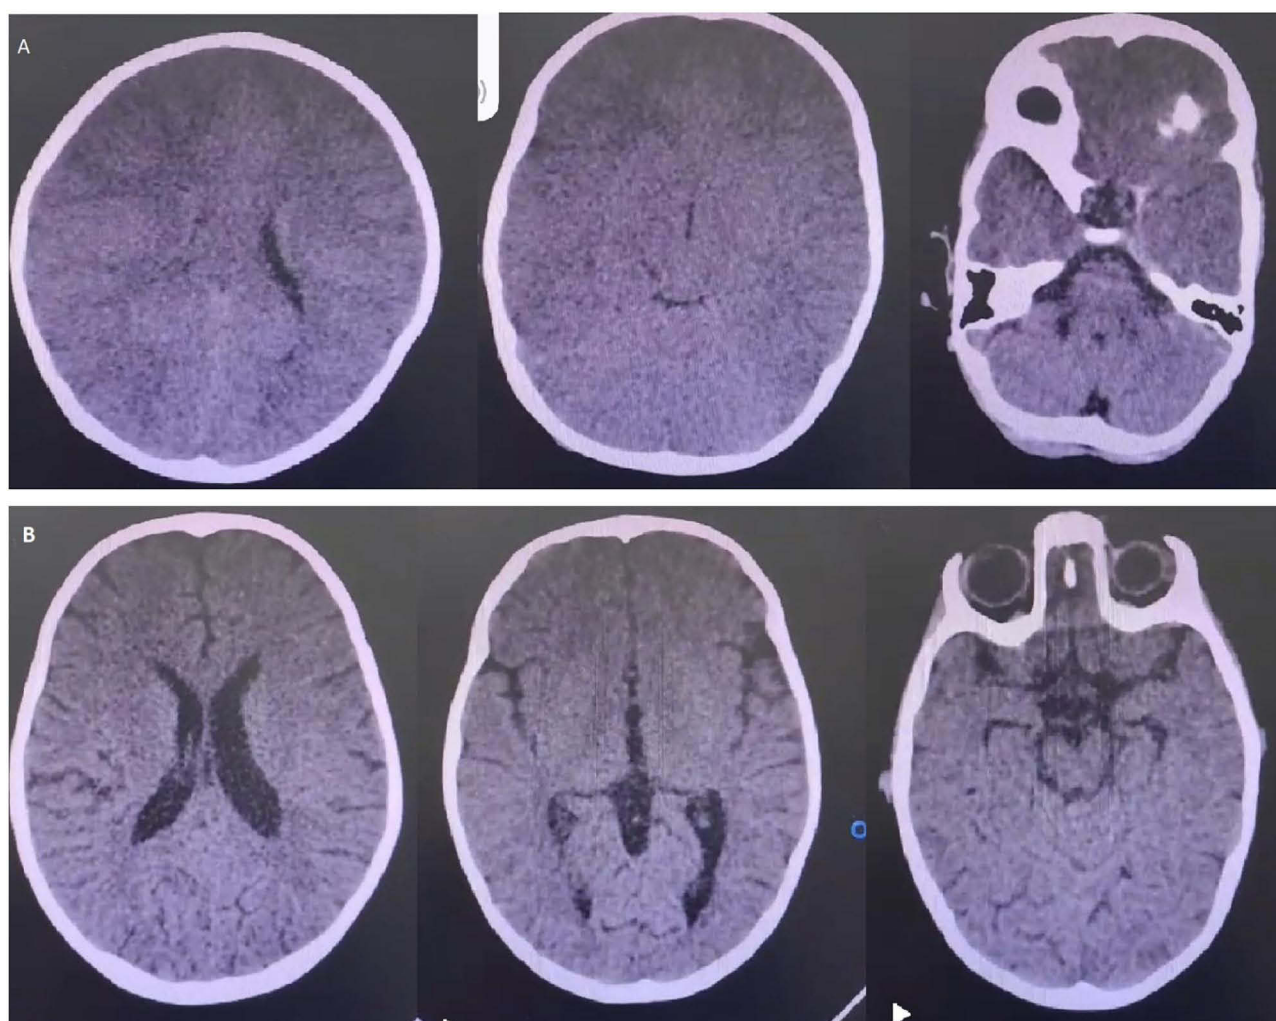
Axial slices from brain CT scan of selected pediatric measles cases. (A) Initial CT scan at time of presentation showed effacement of the ventricular system, sulci and basal cisterns; consistent with increased intracranial pressure. (B) The follow up CT scan showed improvement with restored spaces of sulci and basal cisterns as well as the ventricular system.
